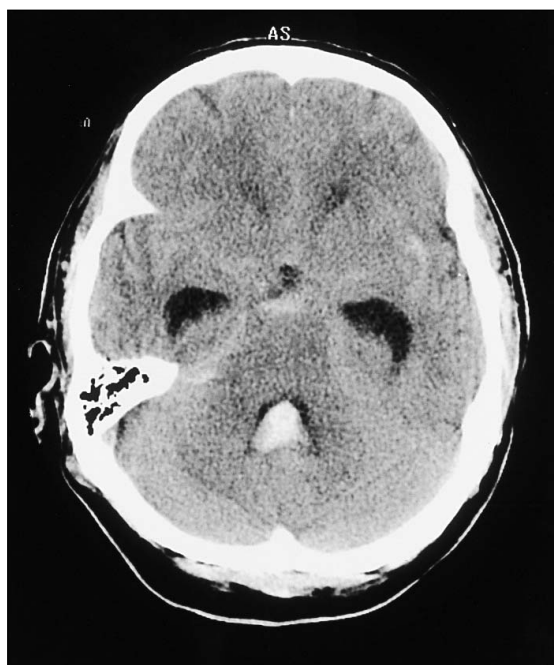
A noncontrast CT head scan shows acute subarachnoid and intraventricular hemorrhage with early hydrocephalus.
